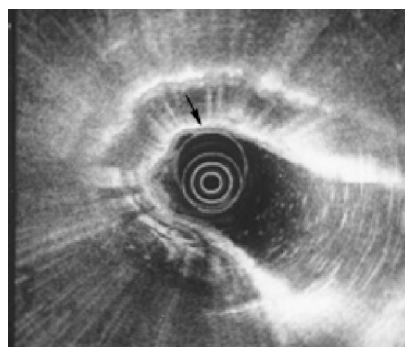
Endoscopic ultrasonography showing a band of bright echogenicity arising from the submucosal layer with shadowing (arrow), representing air in the gastric wall.
